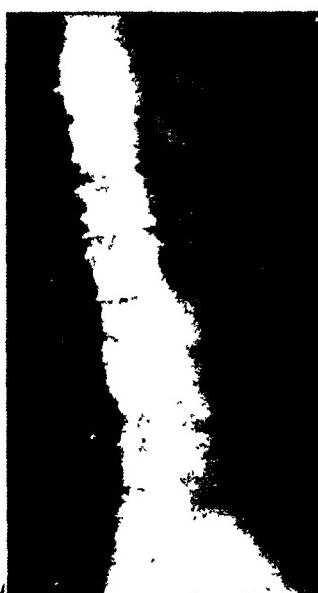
Anteroposterior roentgenograms of lumbar spine of A. C., August 18, 1939, immediately after admission to hospital.
